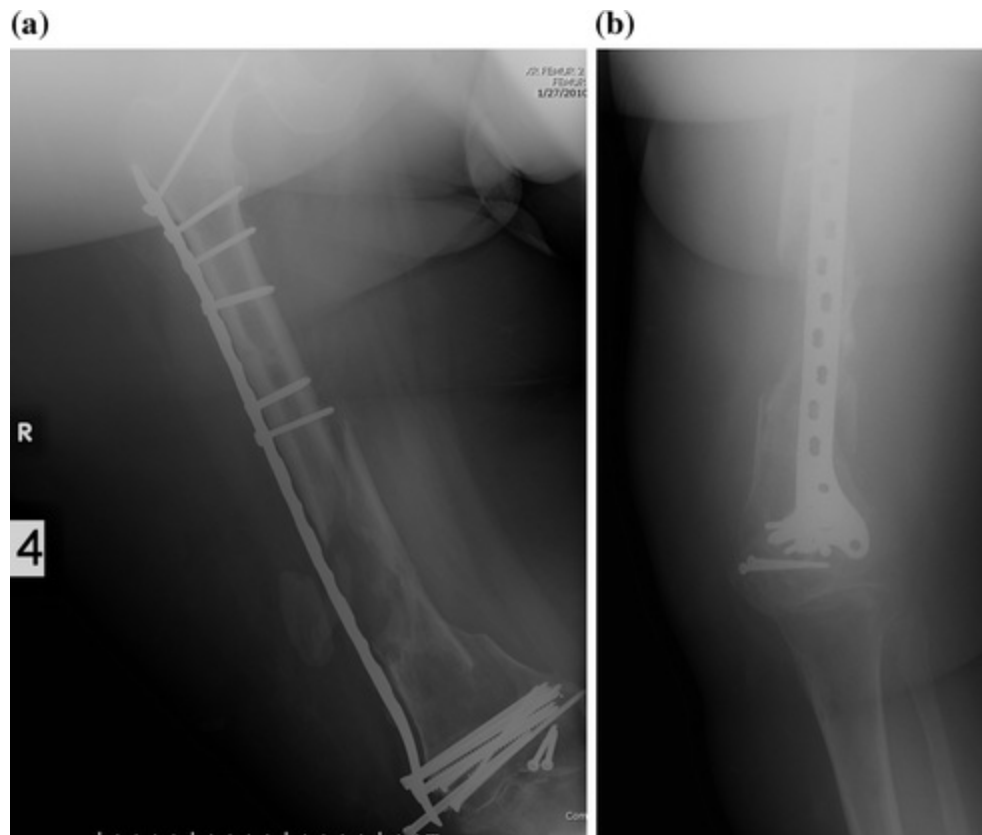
a Anteroposterior and b lateral radiographs of the right femur showing the bending of the original fixation and loss of fixation distally. The large soft tissue density can also be appreciated
